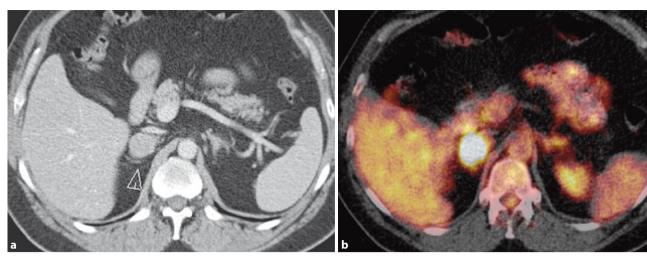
Adrenal metastases. a Appearance of a round mass in the right adrenal gland in staging examination (PET/CT) of a patient with bronchial
